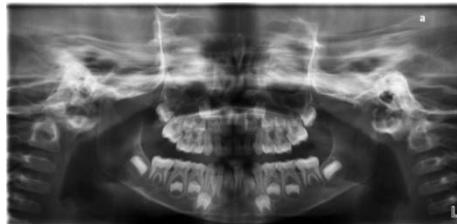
Panoramic radiograph and lateral Cephalogram showing radiographic features of case 1.
